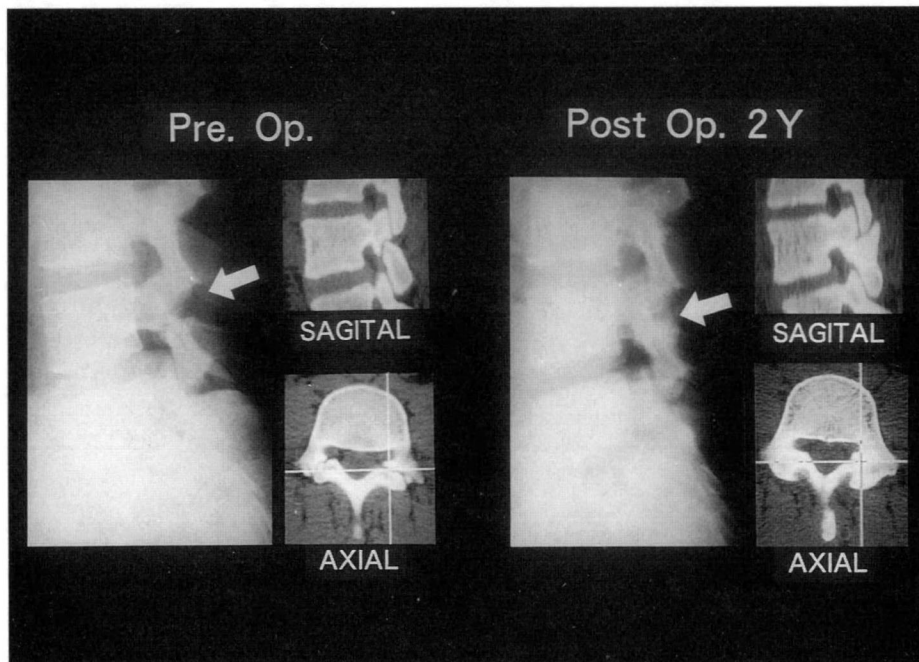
Case 2. A 24-year-old man with L4 spondylolysis underwent successful repair of the defect. CT showed bony fusion of the defect at the pars interarticularis.
